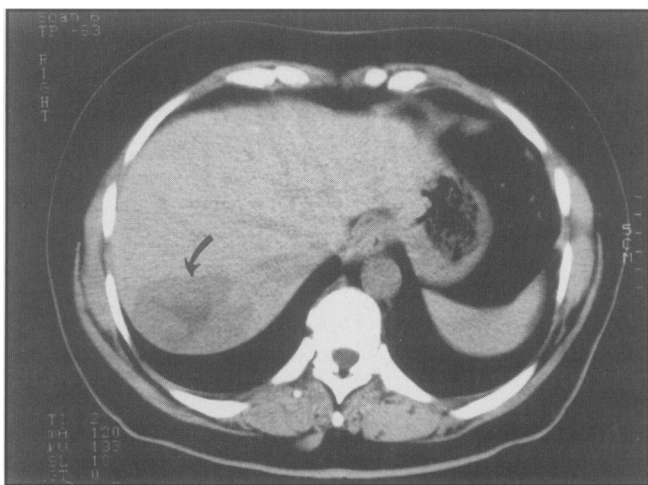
CT scan, from patient 4, demonstrating a hypodense mass in the right lobe, with a central stellate scar (curved arrow).
